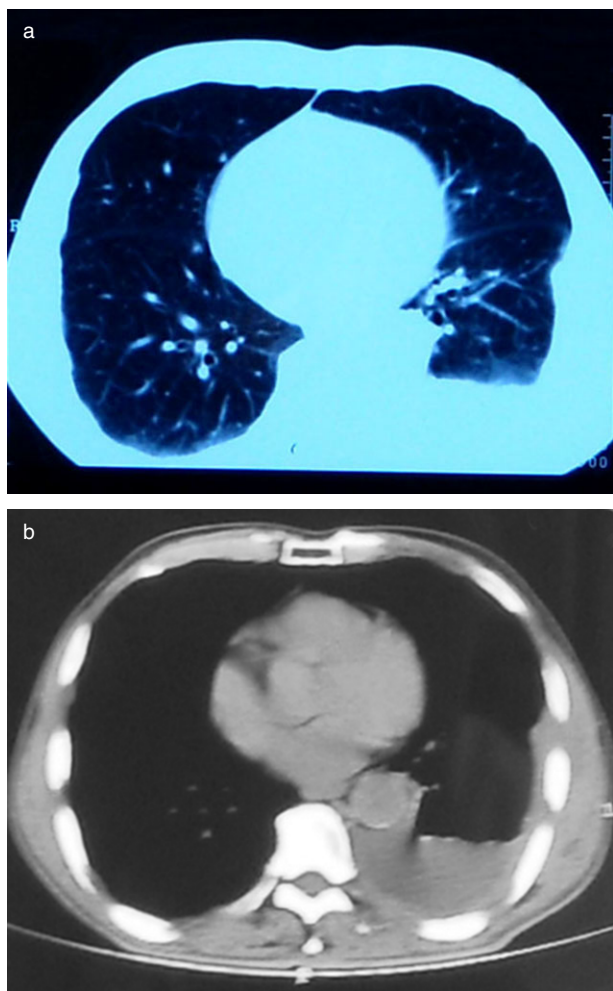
Computed tomography of the chest reveals (a) pleurisy and (b) pleural effusion in the left pleural cavity.
